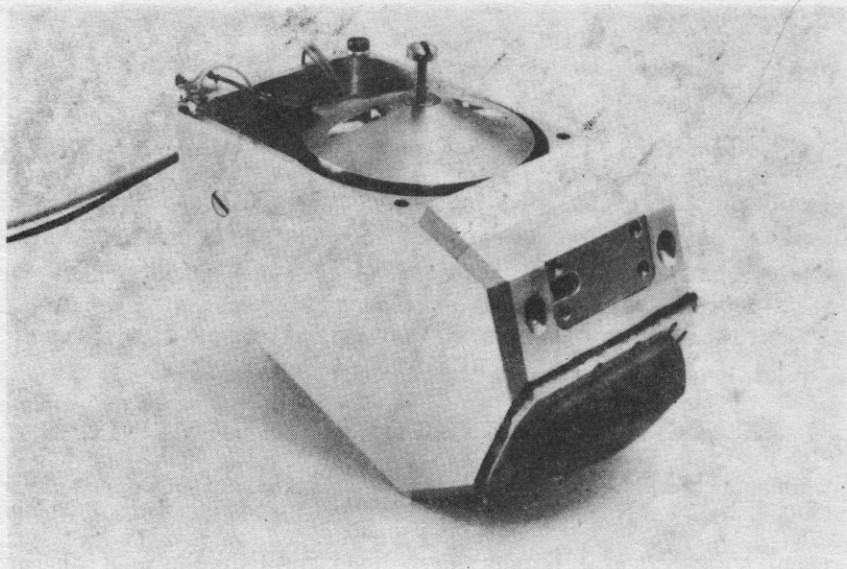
Ultrasonic scanner (overall dimensions  $130 \times 80 \times 75$  mm) with a revolving reflector as shown in Fig. 1, III
